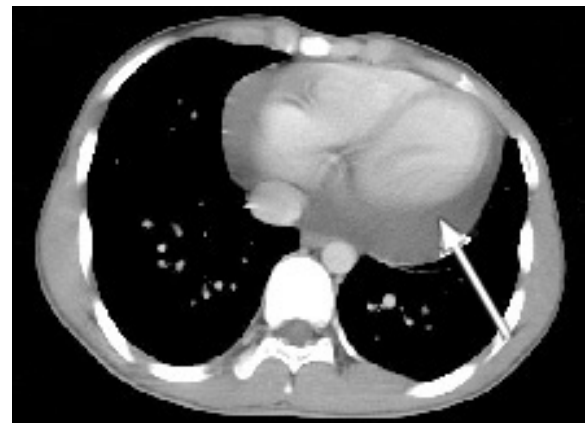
Chest CT image shows an enlarged cardiomeastinal area with pericardial effusion (arrow).
